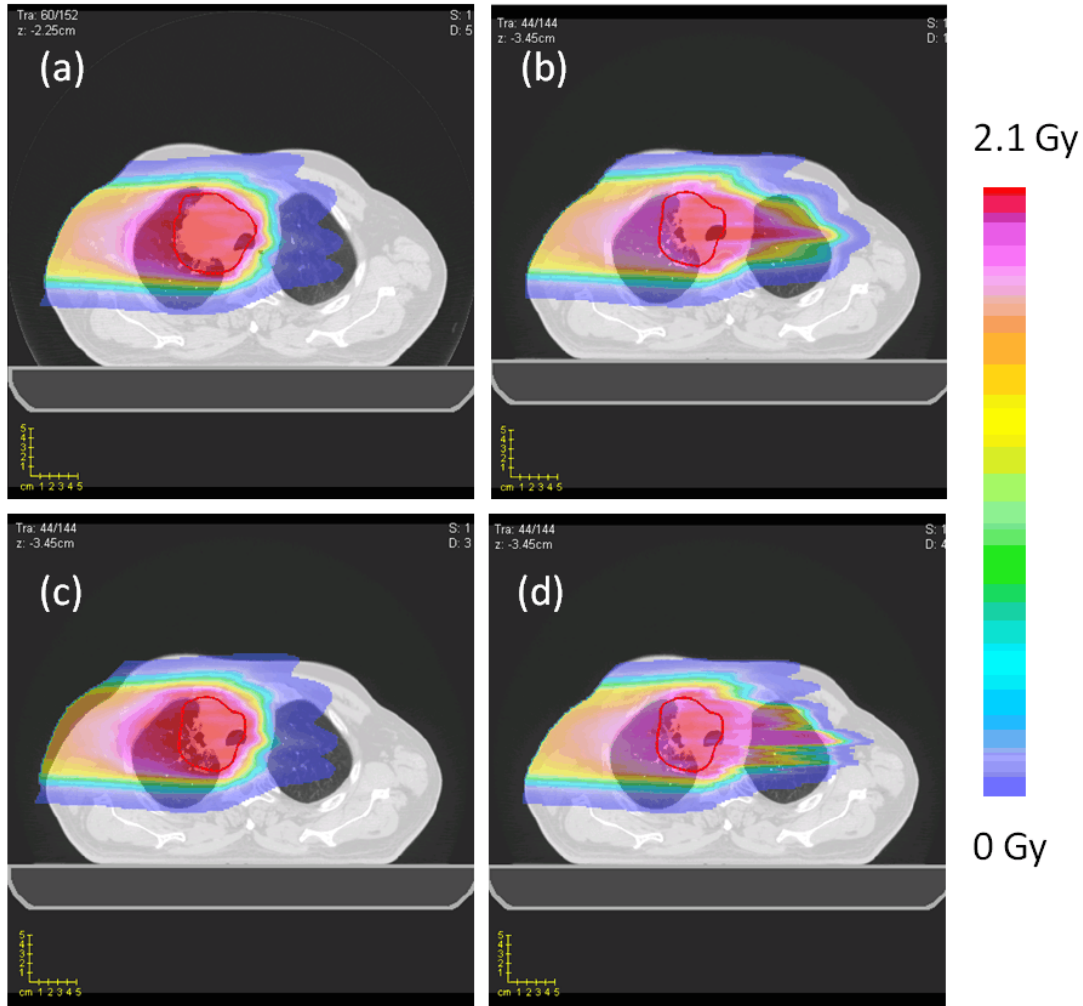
An example of the resultant dose distributions for the lung case for dose approximation. (a) The full dose (TPS) calculation on the lung planning CT (planned dose distribution). (b) The full dose (TPS) calculation on the lung week6 CT (realized dose distribution). (c) The static dose approximation on the lung week6 CT. (d) The range corrected dose approximation on the lung week6 CT.
